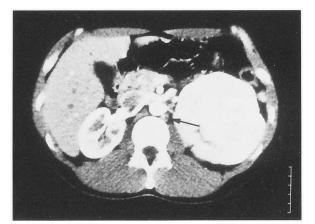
CT revealed a solid tumor 10 cm in diameter with no definite fatty tissue in the upper pole of the left kidney with perihilar and paraaortic lymphadenopathy.
